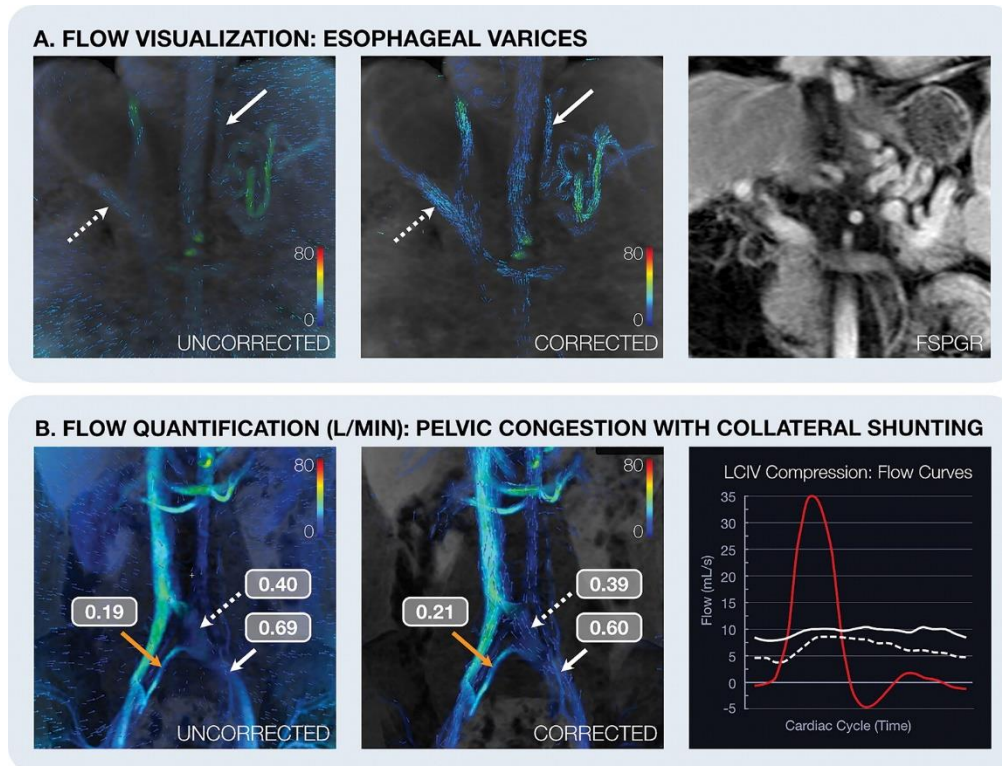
Effect of background phase error correction on flow visualization and quantification. (A) Coronal images in a 53-year-old man with cirrhosis and severe portal hypertension. Postcontrast four-dimensional (4D) flow MRI scans of the abdomen show portosystemic shunting through variceal vessels (solid arrows) that are difficult to discern prior to correction but are clearly seen after correction. The main portal vein (dashed arrows) is also better depicted. Adjacent anatomy is shown in the fast spoiled gradient echo (FSPGR) image. (B) Postcontrast 4D flow MRI scans in a 29-year-old woman with pelvic venous congestion, marked compression of the left common iliac vein (LCIV) under the right common iliac artery, and compensatory collateral flow connecting the LCIV to the right common iliac vein (RCIV). A large discrepancy in the amount of collateral flow (orange arrow) that passes to the RCIV is seen prior to correction. After correction, LCIV flow (0.60 L/min) is equal to the sum of flow within the compressed LCIV and the collateral vein (0.39 + 0.21 L/min). Line graph shows flow curves throughout one cardiac cycle for two locations in the LCIV, where right common iliac arterial flow (red line) suppresses venous return in the LCIV (dashed line and arrows). Venous flow in the LCIV before the collateral (solid line and arrows) remains unaffected.
